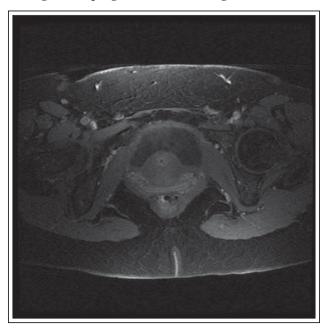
T2 weighted MRI showing circumferential urethral mass.
